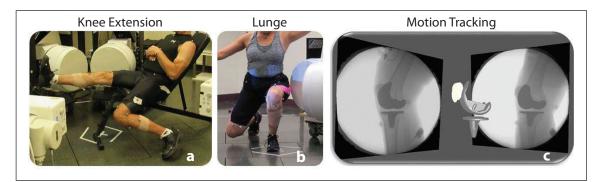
High-speed stereo radiography capture of knee extension (a) and lunge (b). Bone and implant motion tracking (c). Reprinted with permission from: Azhar A, Mannen E, Smoger L, Laz P, Rulkoetter P, Shelburne K. Evaluation of in vivo mechanics for medialized dome and anatomic patellofemoral geometries during knee extension and lunge. Paper presented at: International Society for Technology in Arthroplasty's 29th Annual Congress. October 5-8, 2016; Boston, MA.
